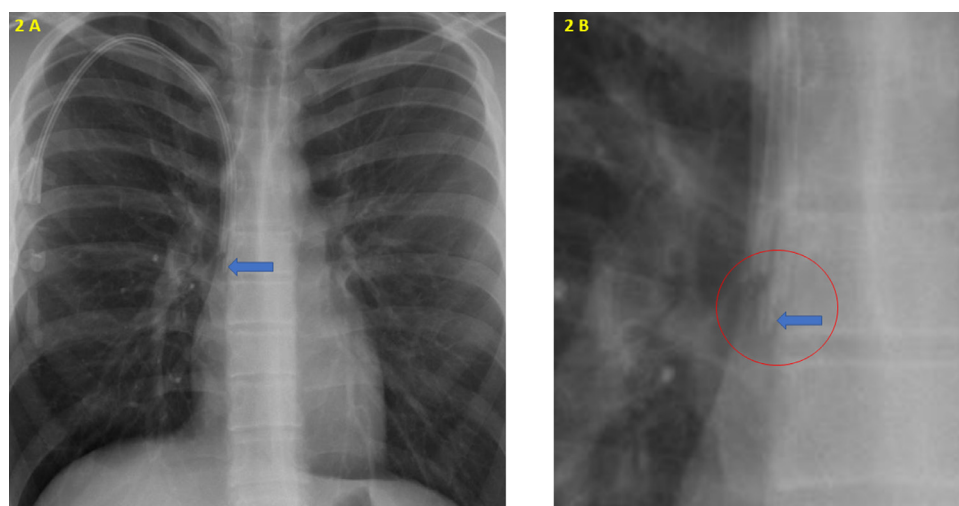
Follow-up chest radiograph. Chest radiograph (A) shows suspicion of discontinuity of the distal tip (arrow) of the distal catheter. A magnified view (B) of the same radiograph shows the discontinuity and malalignment clearly.
